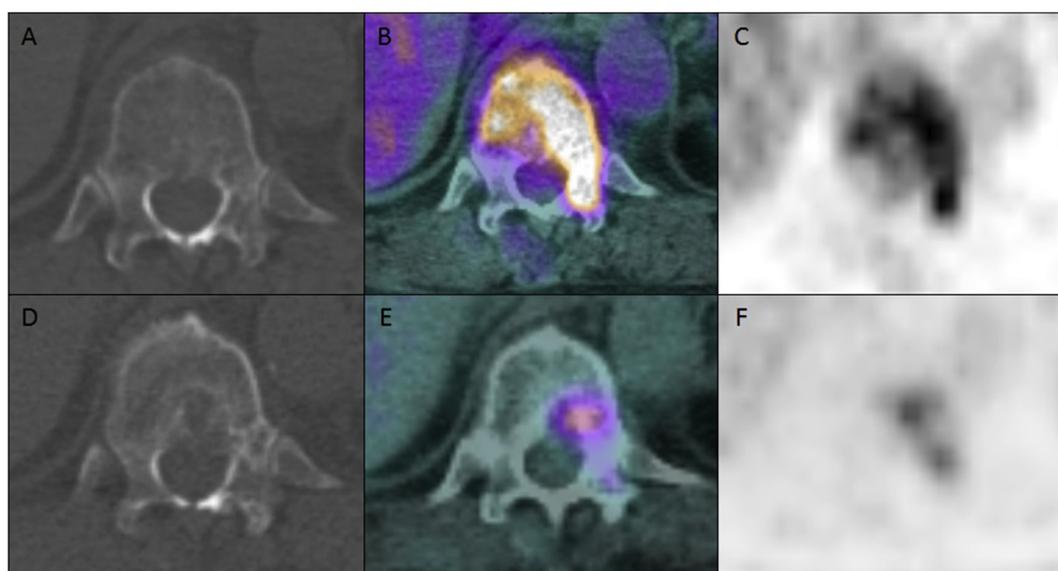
Pre-treatment (A–C) and 6-month post-treatment (D–F) assessment  $^{18}\text{F}$ -FDG PET/CT studies (A and D, 3-mm axial CT; B and E, fusion axial PET/CT and C and F, axial PET) demonstrating a partial response after commencement of bicalutamide. FDG avid disease is seen within the T12 vertebral body extending into the left pedicle on pre-treatment study with very subtle lucency on the CT study. The post-treatment scan demonstrates a marked reduction into FDG activity with patchy marginal sclerosis on the CT scan. CT, computed tomography, PET, positron-emission tomography.
